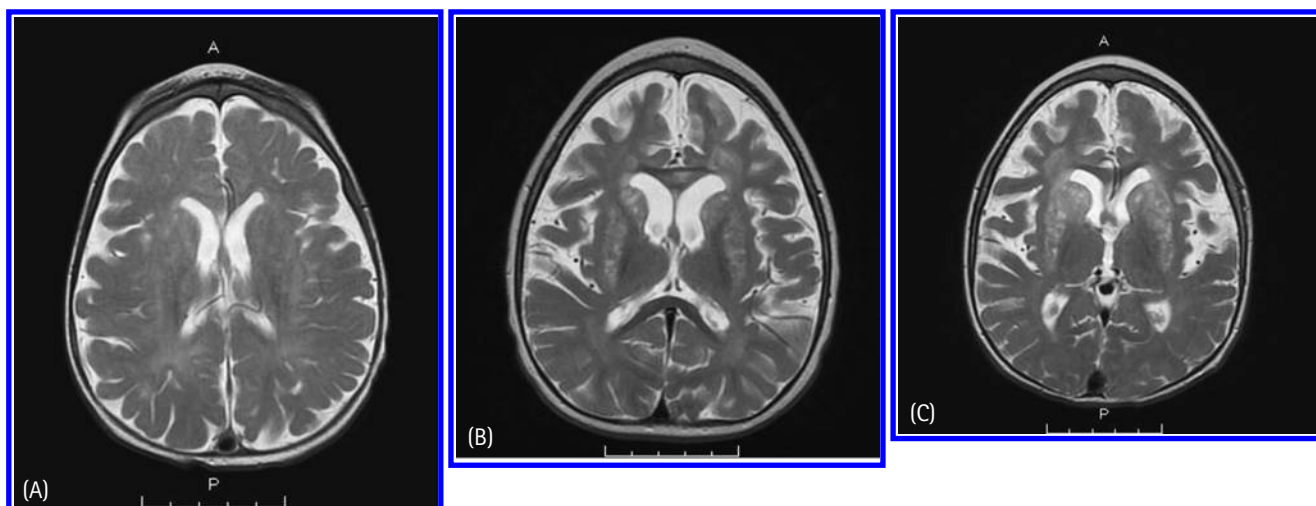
Magnetic resonance images (T_2 signal) of patient JG: (A) at six months of age, (B) at three years of age, recently following an influenza A infection, (C) at three years and two months, after two months of treatment with metronidazole and N-acetylcysteine. Note progressive atrophy and encephalomalacia of putamen, caudate, lentiform nuclei, and periventricular white matter with cystic changes. The brainstem and cerebellum appeared normal.
